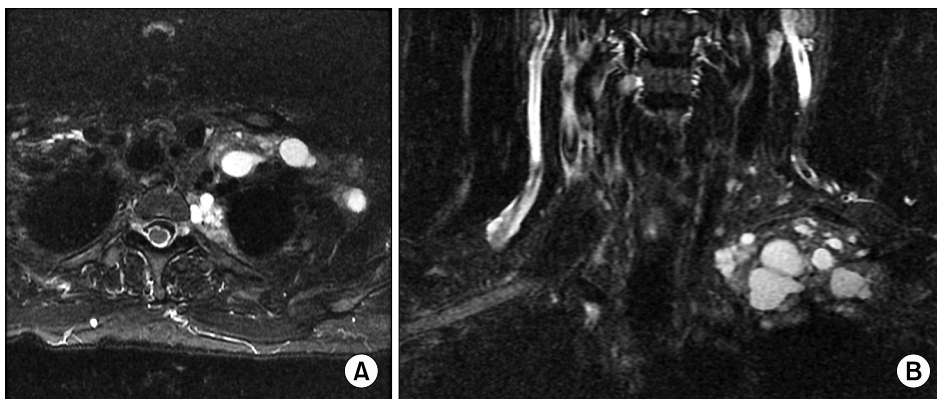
Axial (A) and coronal (B) MRI images showing paraspinal, left supraclavicular and left axillary cystic lesions, the largest of which was 6.3×3.5×4.2 cm.
